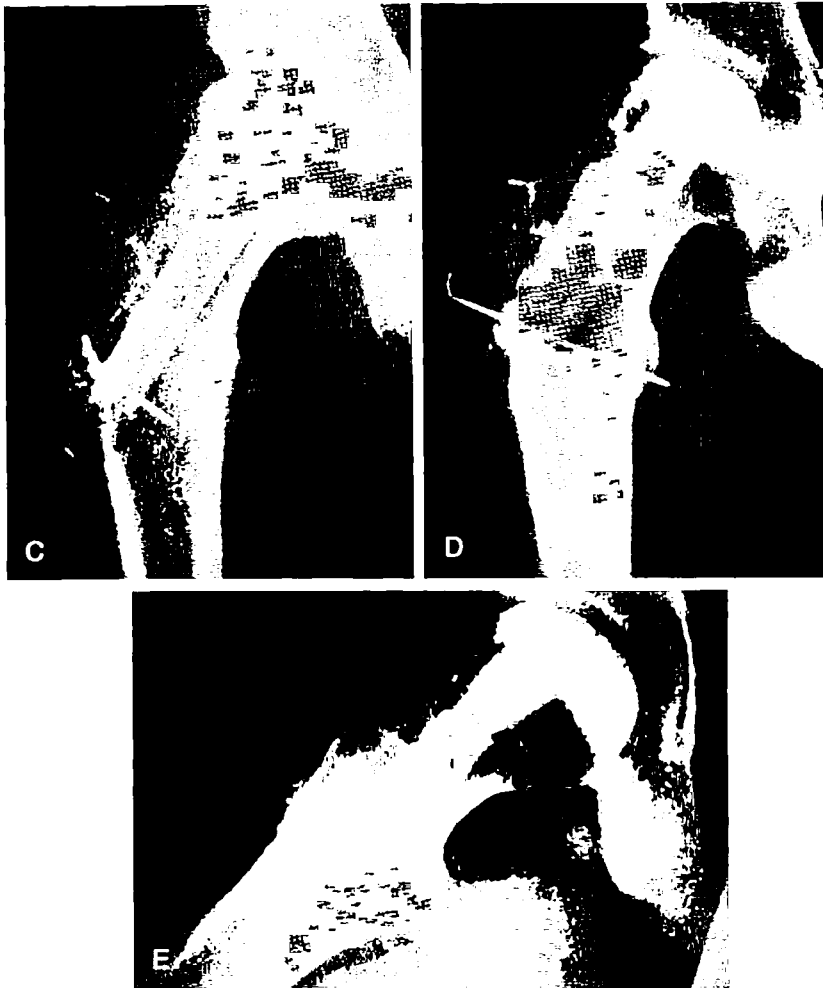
(Continued). C. AP radiograph 1 month postoperatively from a free vascularized fibula transfer. D. AP radiograph 6 months postoperatively in the same patient. E. Lateral view 6 months postoperatively. (Courtesy of Kevin Plancher, MD, New York, NY.)
